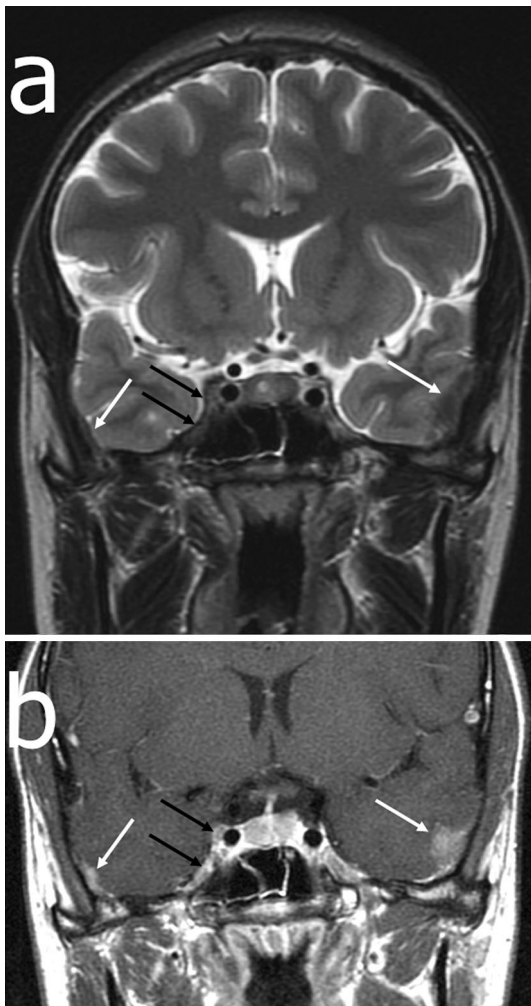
T2-weighted (a), and gadolinium-enhanced (b) coronal magnetic resonance images of the cavernous regions. *Black arrows* indicate the thickened dura mater of the right cavernous sinus, showing low signal intensity on T2-weighted images and gadolinium enhancement. *White arrows* indicate dural focal thickenings of low signal intensity on T2-weighted images and gadolinium enhancement in both the anterior temporal regions, more pronounced in the *left side*. Note also a median-right paramedian adenoma of the anterior pituitary gland, as an incidental finding
